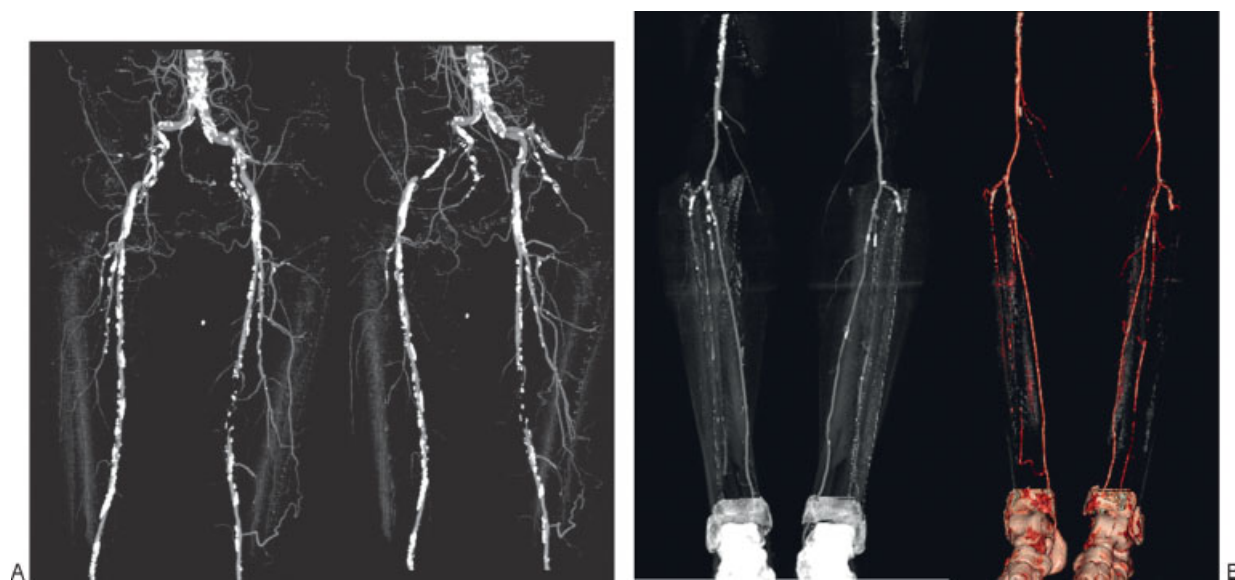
Computed tomographic angiography of 68-year-old diabetic woman with claudication due to inflow disease. (A) Maximal intensity projections of the pelvis and thighs show occlusion of the right external iliac artery and left superficial femoral artery. Note heavy calcification of all visualized arteries. (B) Maximal intensity projection (right) and shaded surface reconstruction of the calves (left) show single vessel runoff bilaterally via the posterior tibial arteries.
